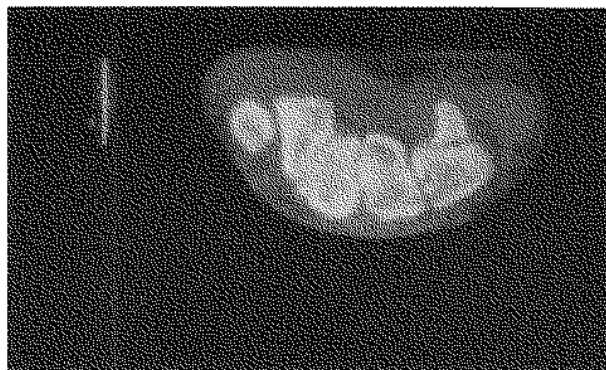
Fracture of the hook of the hamate seen on CT-scan.
